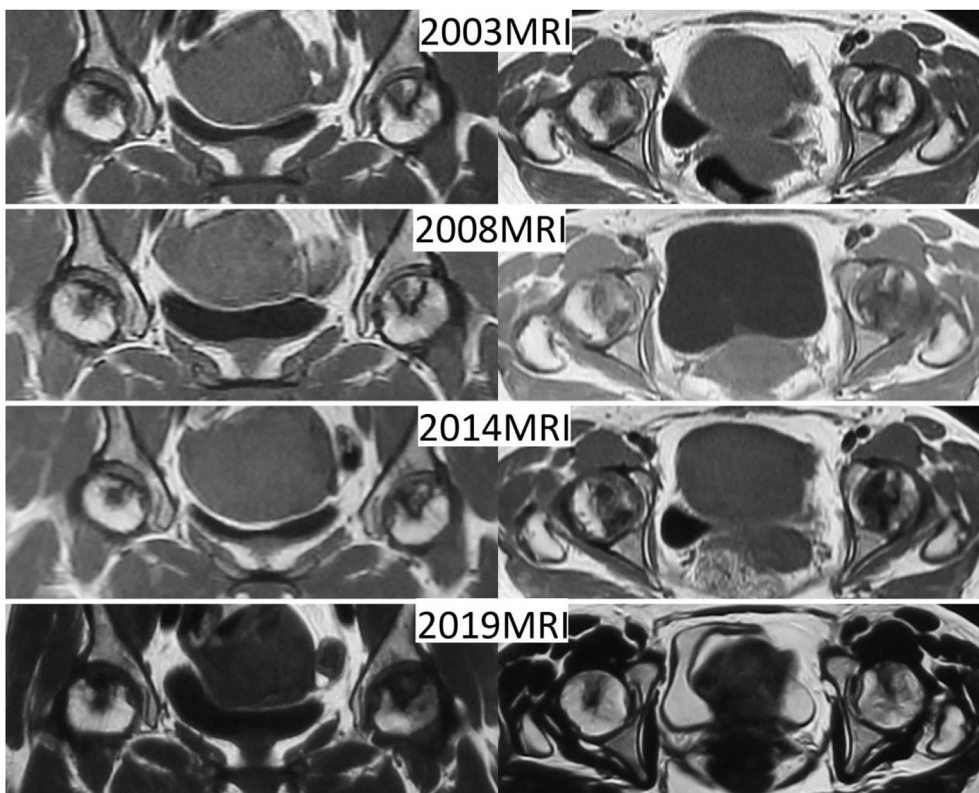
MRI from a 35-year-old female (patient number SARS03017) with ONFH received HGF therapy in 2003. Series MRI (from 2003 to 2019) showed the development of focal low signal lesion. MRI in 2019 suggested a complete sclerosis (low signal lesion) in the necrotic lesions. HGF = Huo-Gu formula; MRI = magnetic resonance imaging; ONFH = osteonecrosis of the femoral head.
